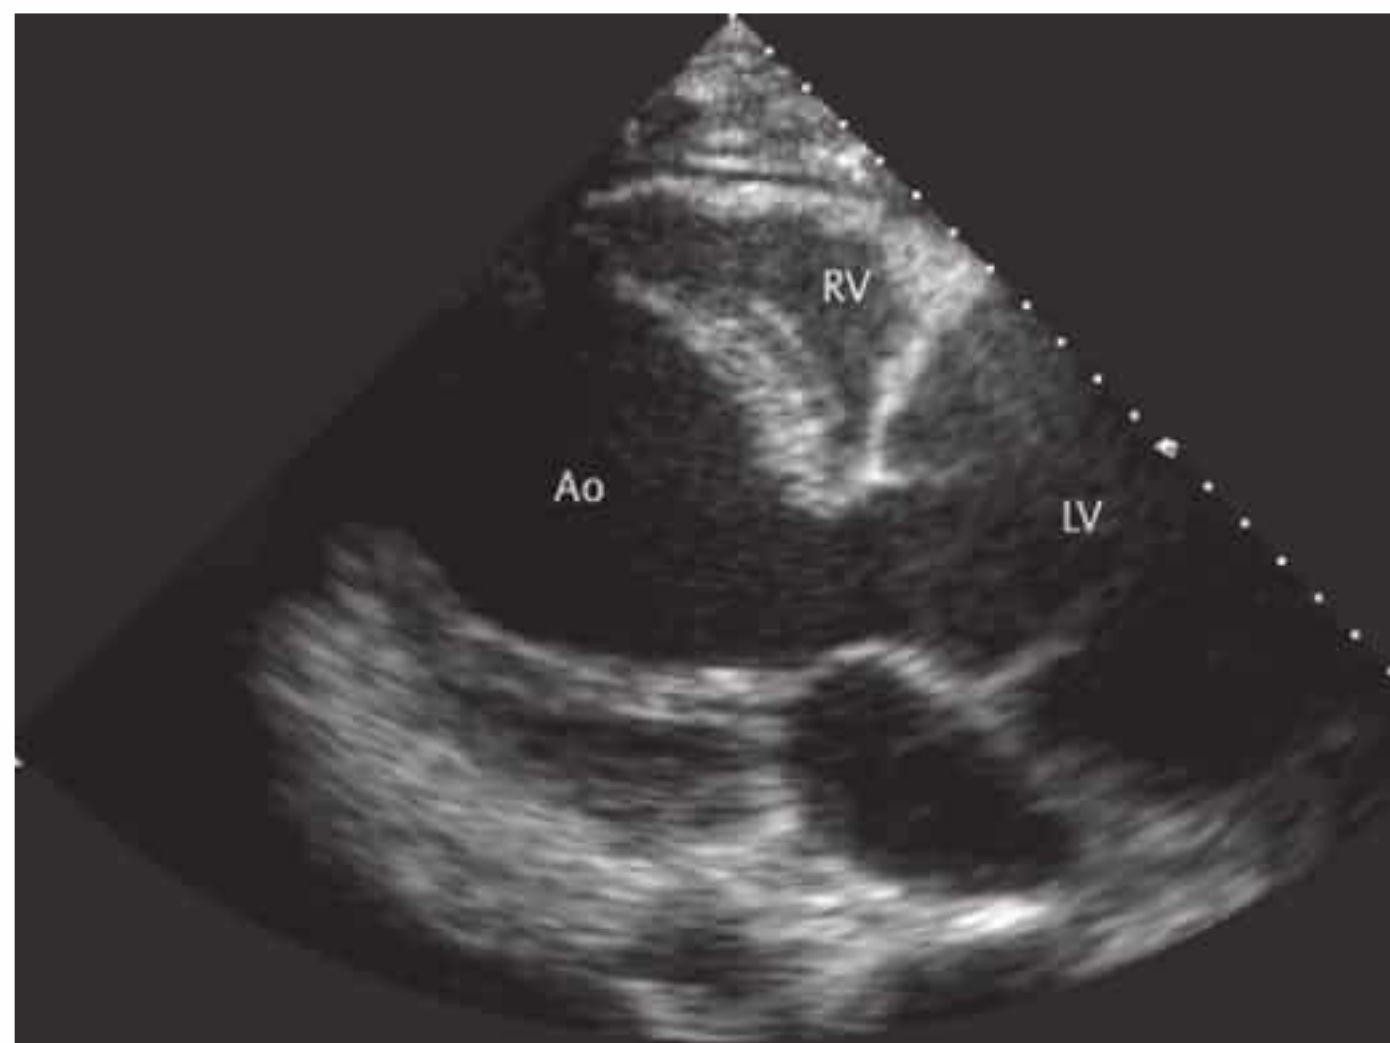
TEE. Parasternal long-axis view shows a conspicuous aneurysm of the aortic bulb in a patient with Marfan syndrome.
